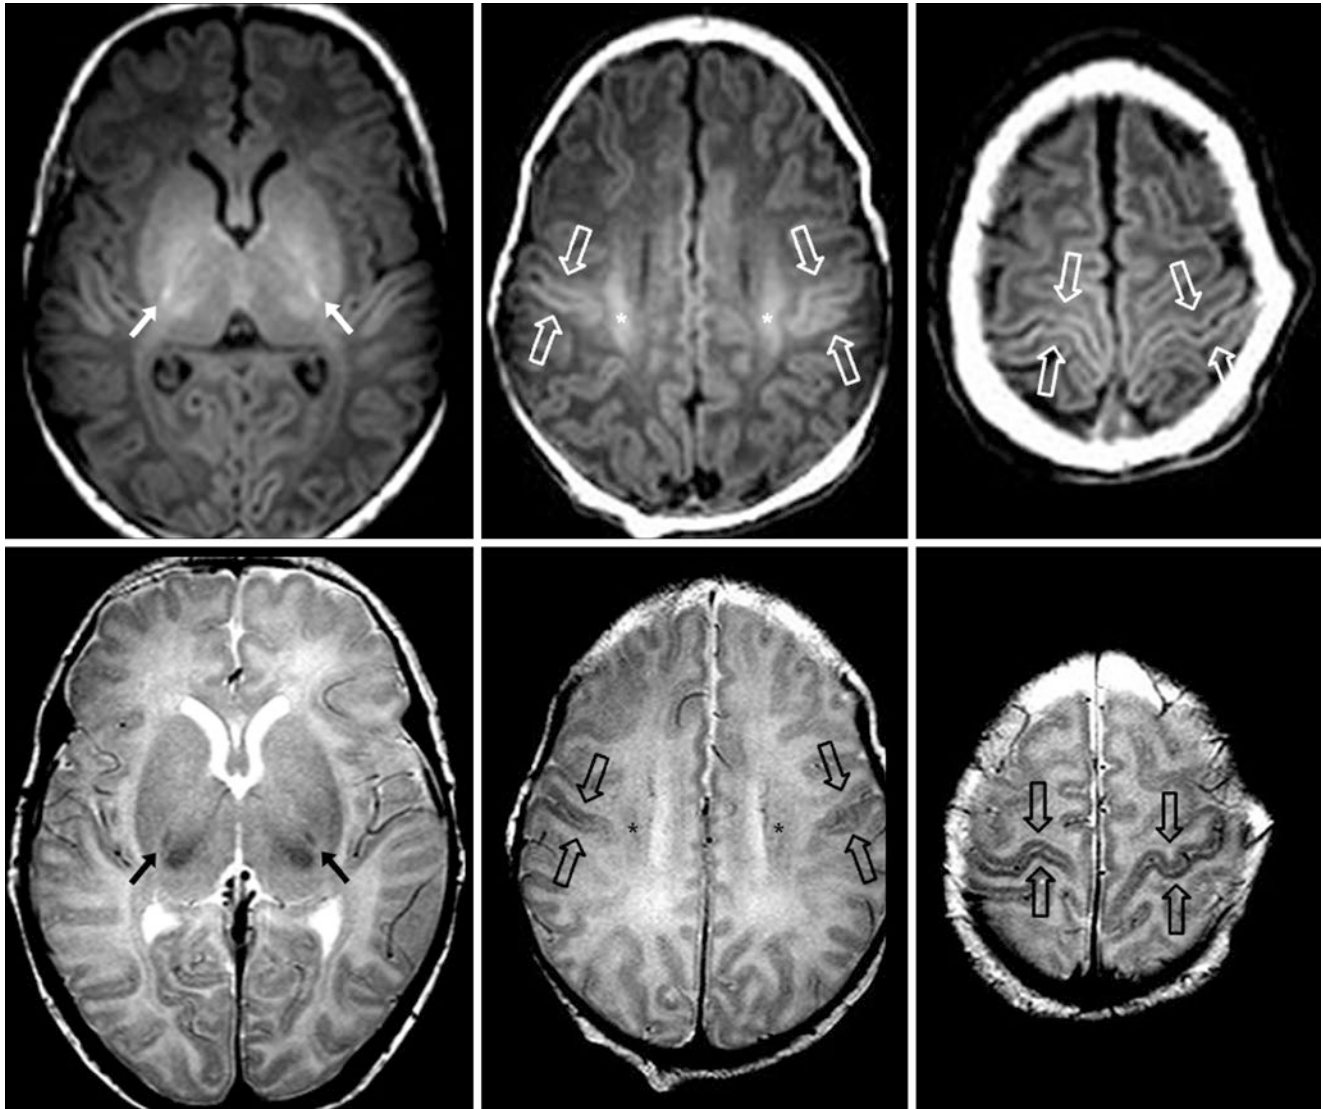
A 5-day-old term neonate had a normal 3T MRI with GE T1WIs (top row) and SE T2WIs (bottom row). The PLIC/corticospinal tracts (CSTs) (arrows) are quite bright on GE T1WI; they are less visible, but present, on SE T2WI. This finding is contiguous with T1-bright
